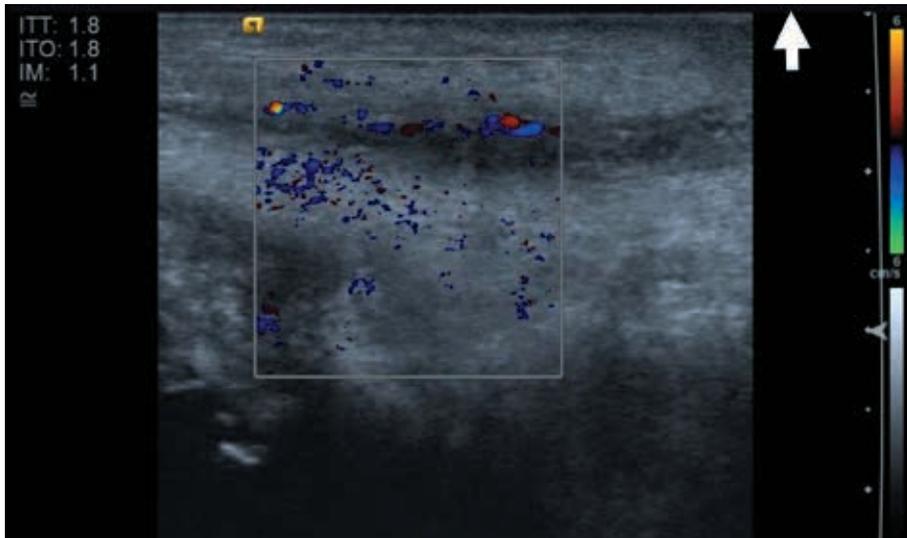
Distal spermatic vein ultrasound image showing absence of venous flow and thickened tunics, as typically seen in thrombophlebitis.
